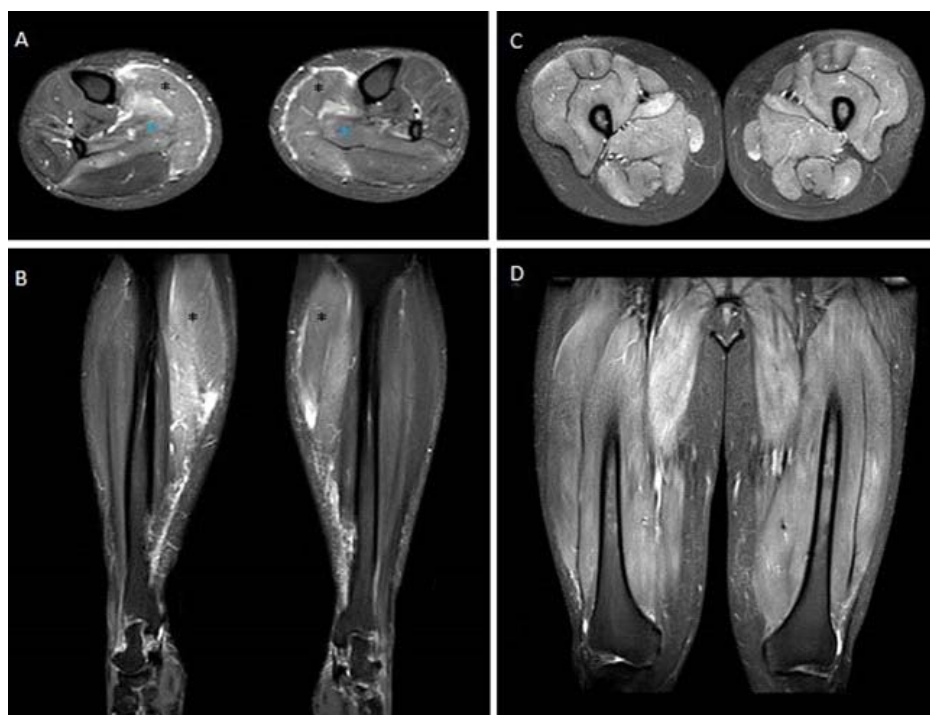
MRI (STIR) of lower limbs
